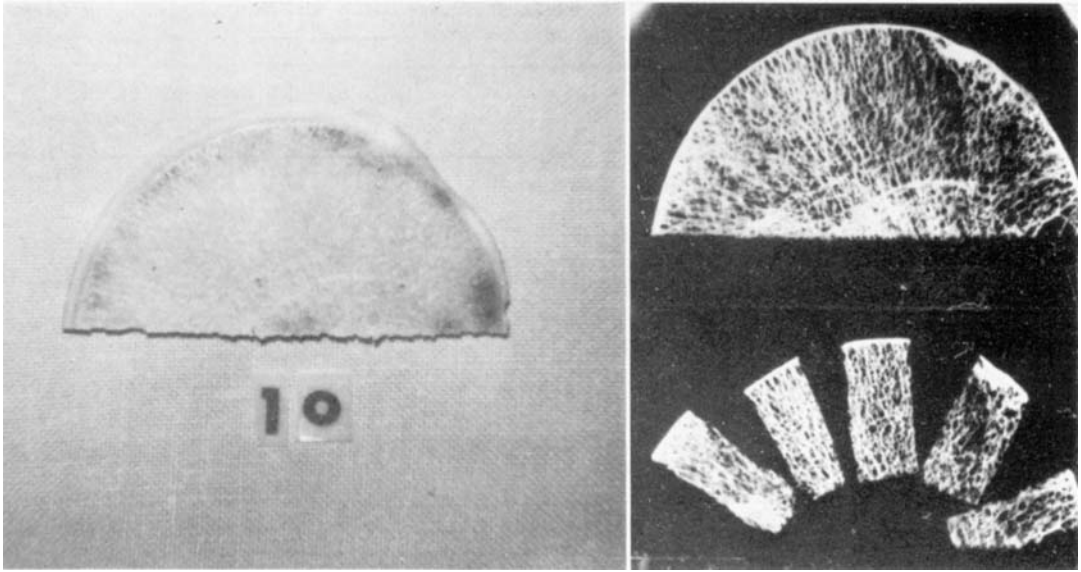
Slice from the normal femoral head of a male aged 61 (left). The x-ray shown in the right side of the figure shows the distribution of the bone segments.
